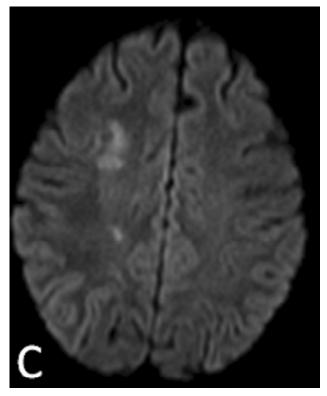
A 32-year-old male presented with seizures and unconsciousness since one day and underwent MRI scan (A) axial FLAIR and (B) axial T2 weighted images demonstrate high signal area in the right high frontal lobe with restriction on the diffusion-weighted image in the corresponding areas (C).
